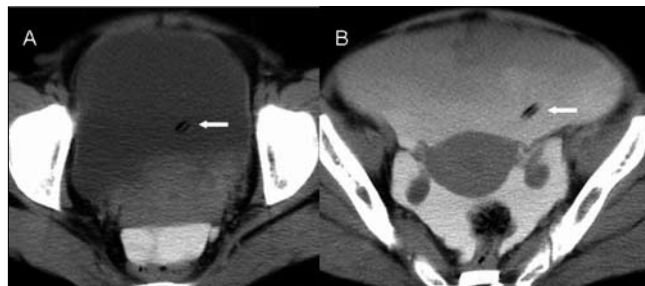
CT cystogram: Axial image A showing Foley catheter within the bladder and B showing Foley catheter into the left side of the peritoneal cavity.
